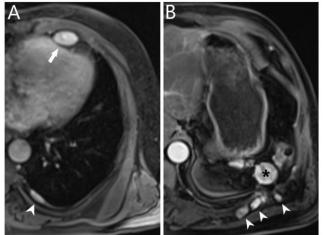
Contrast-enhanced MR images obtained in the axial plane show a similar pattern of enhancement in the mass formation at the left anterior diaphragmatic level (arrow) and pleural plaque-like soft tissue in the lower lobe of the left lung (arrowhead) (a), as well as spleen lodge soft tissue (asterisk) and ovoid nodular formations in the area adjacent to the existing defect in the abdominal wall (arrowheads) (b)
